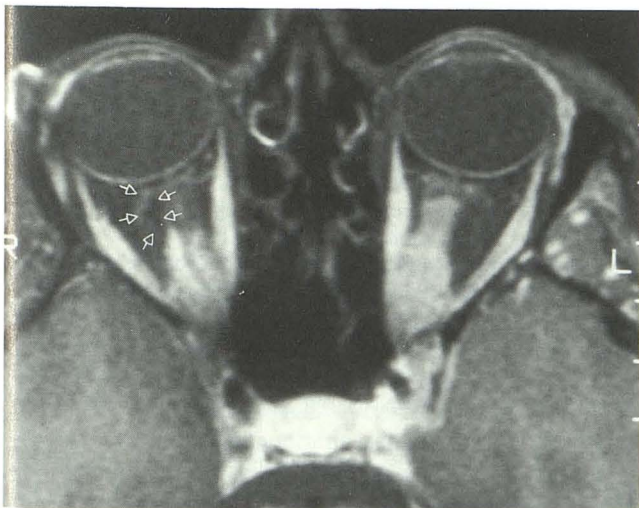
Axial T1-weighted MR image (600/20/2) (obtained with fat suppression after Gd-DTPA administration) showing bilateral optic nerve meningiomas. The anterior aspect of the right sheath meningioma begins approximately 10 mm posterior to the globe and extends along the optic nerve through the optic canal. Arrows highlight the margins of a fluid accumulation eccentric to the distal right optic nerve. The tumor on the left approximates the posterior aspect of the globe and extends posteriorly to involve the intraorbital and intracranial optic nerve.
